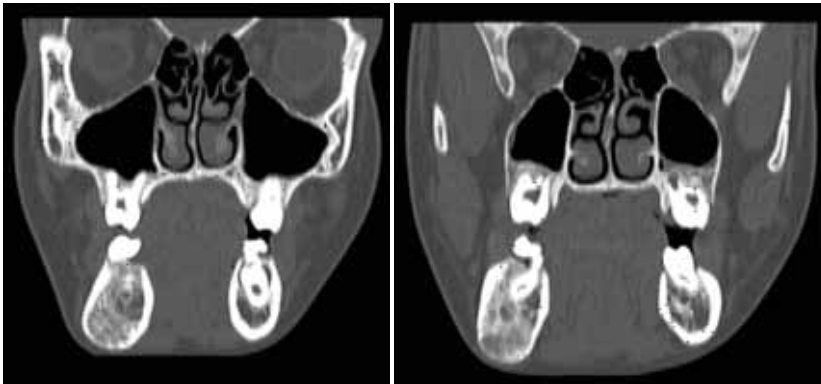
Coronal CT showing irregular trabecular pattern with thinning of lower border of mandible.
